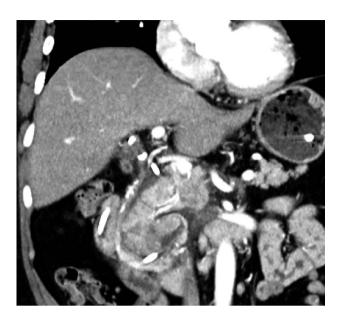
Computed tomography demonstrated a large tumor in the distal common bile duct.
